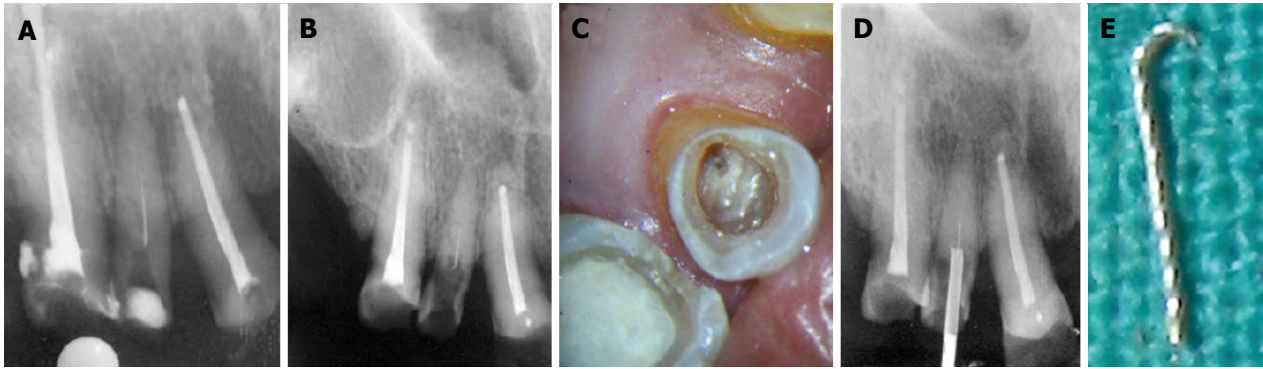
The extractor is inserted into the groove and locked the end of the fragment by the screw tightened between the plunger and the internal embossment. A: Periapical radiograph: Separated instrument is visible in middle 3rd of calcified root canal in maxillary right lateral incisor; B and C: Making a channel around the separated instrument to keep the broken instrument in the center of the tube of Masserann Kit; D and E: Engaging tube of Masserann Kit with the separated instrument and removal of the fragment from root canal.
